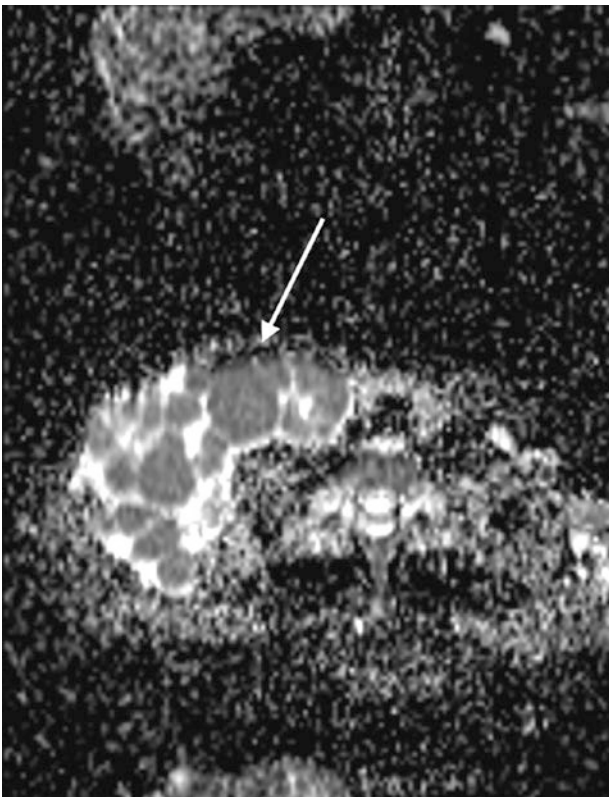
Apparent diffusion coefficient (ADC) map from diffusion-weighted MR imaging shows hypointense (dark) signal in right-sided cervical lymphomatous nodes
